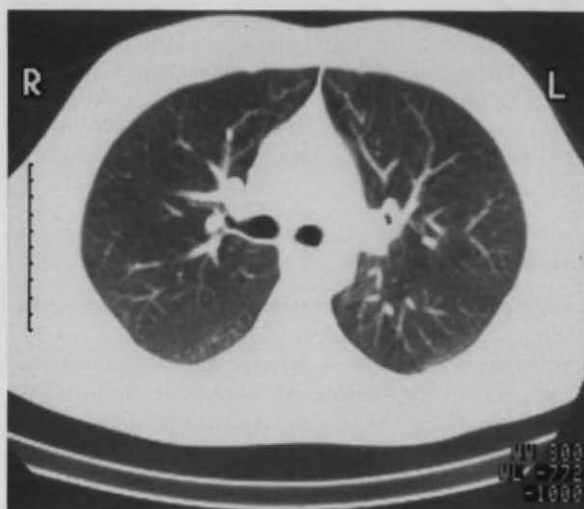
CT scan, at the same level as Figure 4.33 but at a different image setting to show pulmonary vessels which are not visualized at the settings required to show mediastinal structures. The translucencies near the centre are the two main bronchi.
